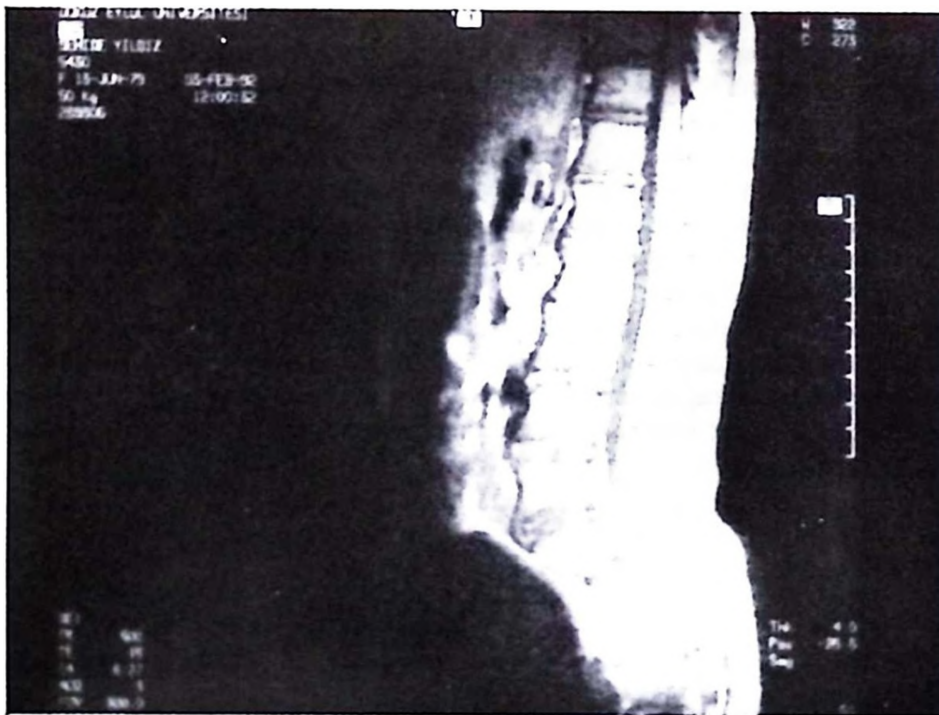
In the sagittal T₁ weighted MR images, caudal spinal cord seemed thinner and dural sac terminated at S₁ level, fatty tissue filled the rest of the canal. (SE, TR 500, TE 15)
